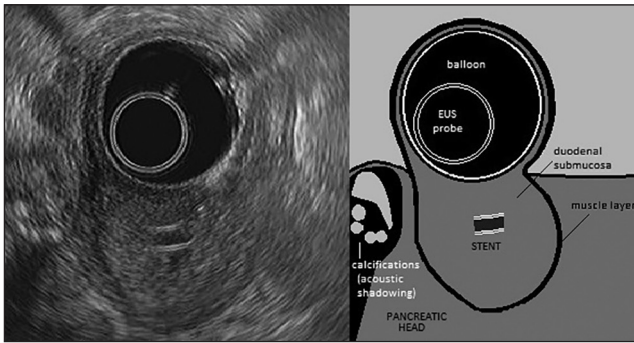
Endoscopic ultrasound view of the pancreatic head showing signs of chronic calcifying pancreatitis and the biliary stent surrounded by thickened duodenal wall that appears with a pancreas-like echostructure
